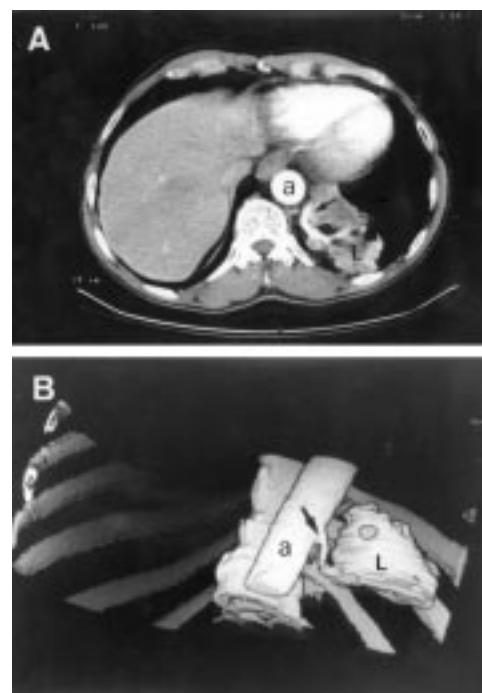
Spiral CT scan of case 3. (A) Contrast enhanced CT axial image showing an anomalous systemic artery (arrow) feeding the pulmonary lesion (L) in the left lower lobe. (B) Left oblique view of helical CT angiogram demonstrating the anomalous artery (arrow) originating from the left wall of the thoracic aorta (a).
